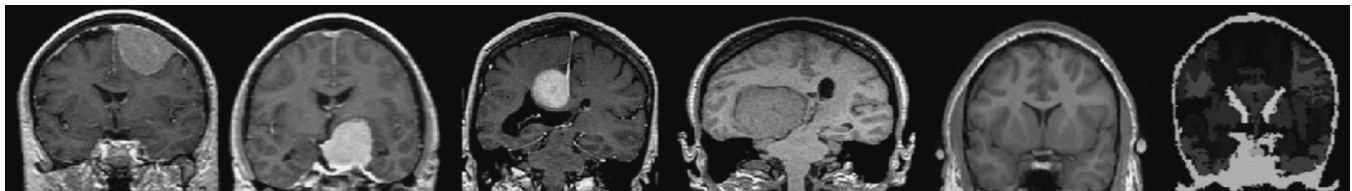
Coronal slices of the data set. From left to right: patients from 1 to 4, atlas MRI and atlas labels.
